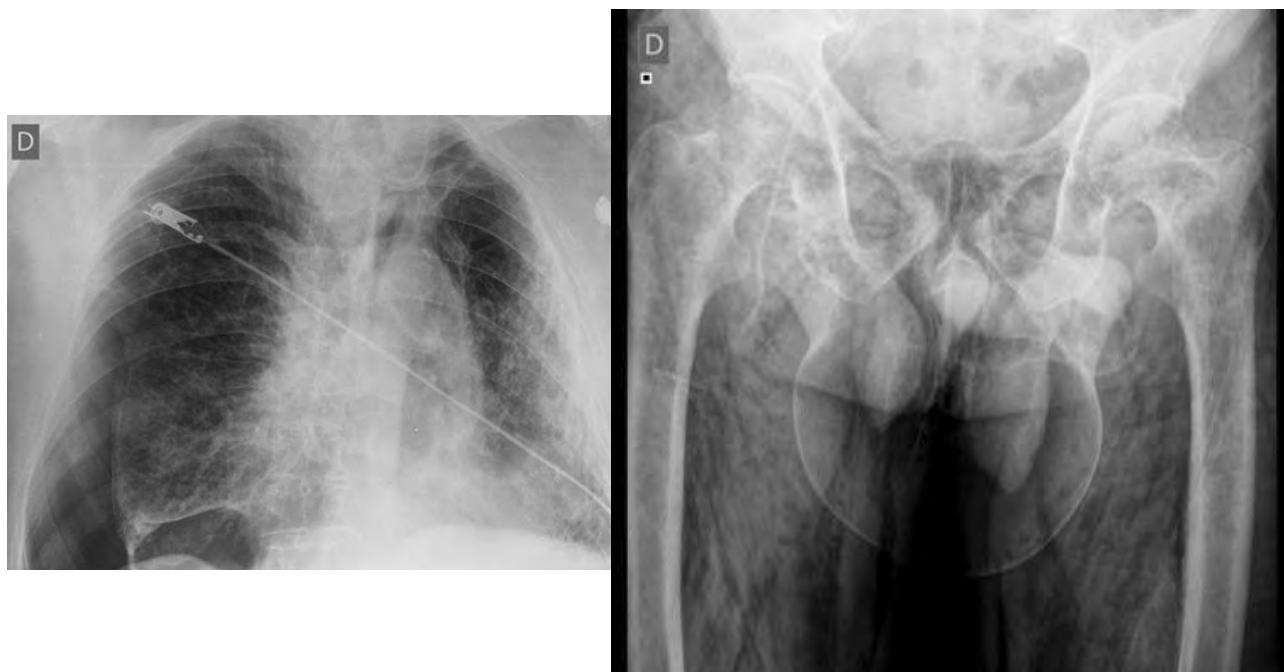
Left: chest X-ray showing right pneumothorax. Right: hip X-ray showing subcutaneous emphysema in the legs and scrotum.
